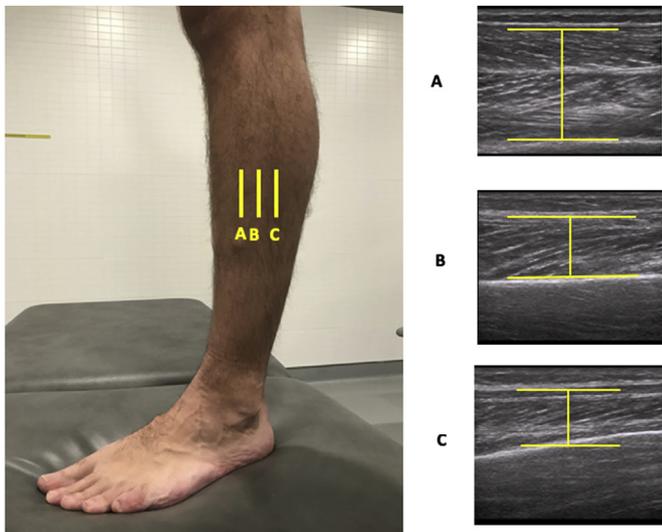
Ultrasound imaging thickness for the TA, EDL and PER muscles in longitudinal view.
